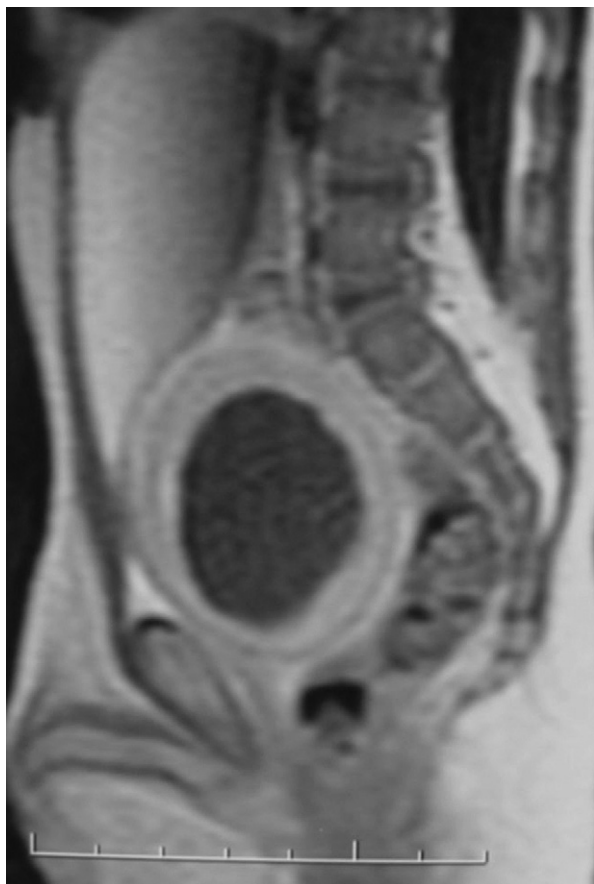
MRI showing the Müllerian cyst.
